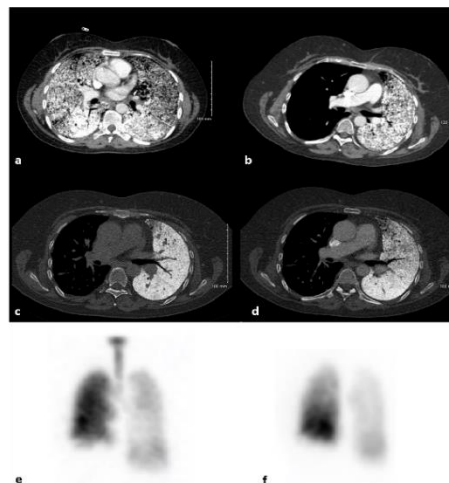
a) & b) Axial CT image at mediastinal window and c) & d) bone window. a) Axial baseline Chest CT image shows bilateral diffuse intra-alveolar as well as interlobular septal calcifications; b) Contrast-enhanced CT imaging one year after right pulmonary transplantation. Right transplanted lung appears more expanded than the restrictive left native lung involved by PAM; c) & d); c) Three years after right lung transplantation expiration d) and inspiration acquisitions show density changes between expiration and inspiration phase; e) & f): e) Planar images of ventilation after KRYPTON inhalation and f) perfusion after injection of 150MBq of technetium PULMOCIS, three years after transplantation. Left lung shows diffuse decrease in ventilation and perfusion: the relative perfusion contribution was 77.6% and 22.4% for the right and left lungs, respectively.
